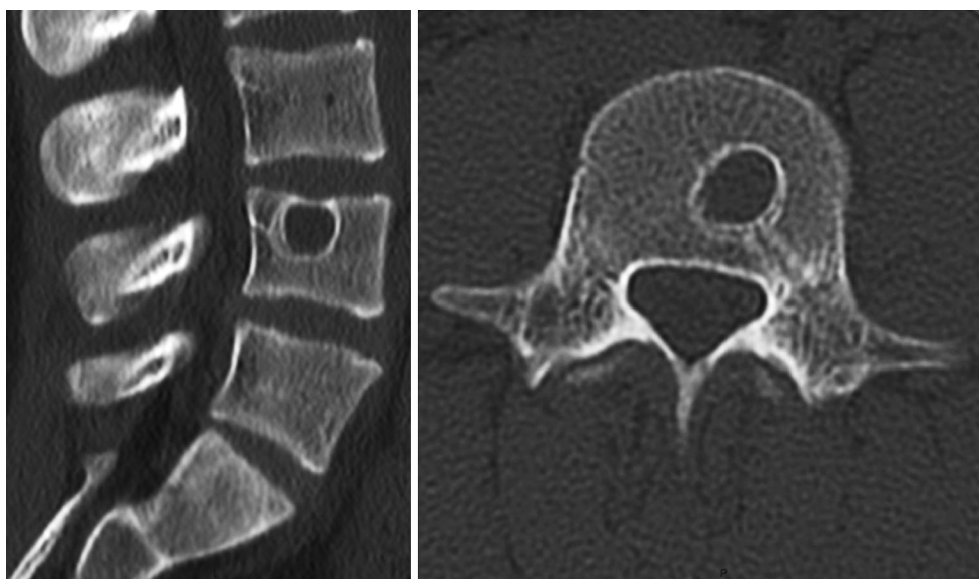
CT at the final follow-up. CT scan performed 7 months postoperatively showing beginning of bony healing
